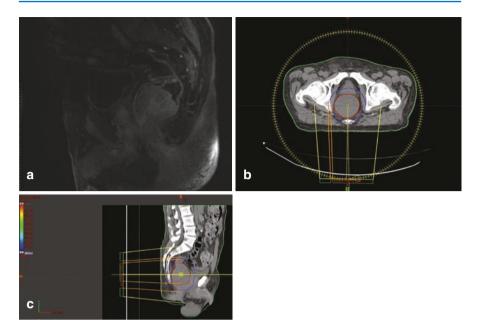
(a) MRI shows local recurrence findings. (b) Radiotherapy plan in the axial plain, red, primary tumor; purple, planned treatment volume. (c) Radiotherapy plan in the sagittal plain, red, primary tumor; purple, planned treatment volume (MRI image was used with permission from the Radiology Clinic of Tepecik Research and Training Hospital, Health Sciences University)
